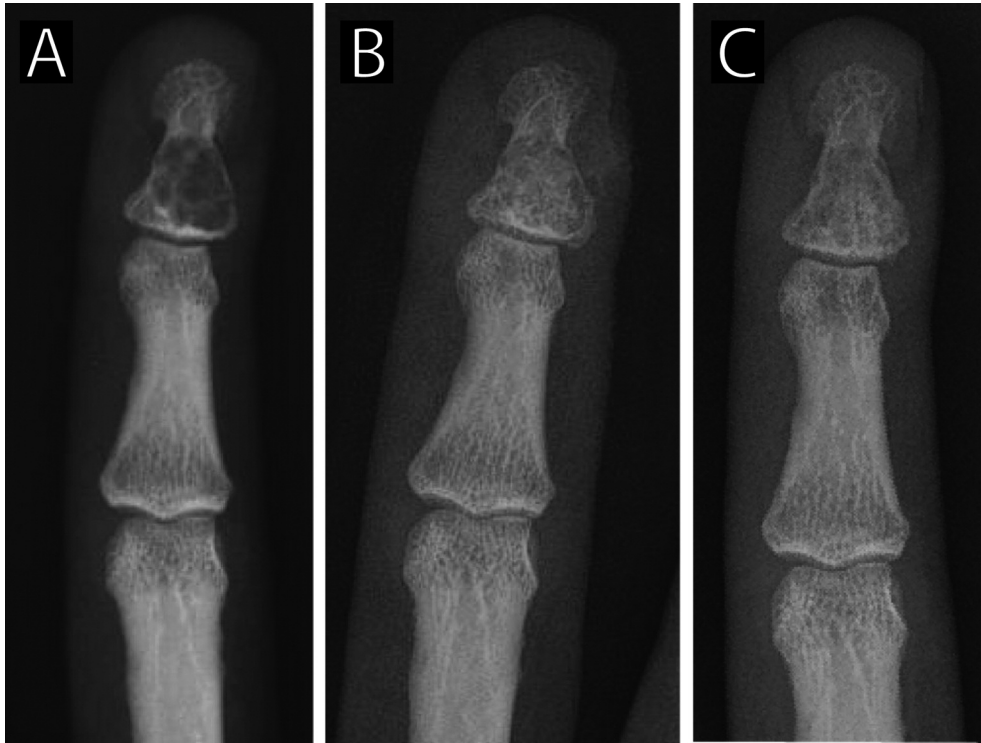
Plain radiographs from the case of a 35-year-old female with distal phalanx enchondroma at presentation (A), and at 3 months (B) and 1 year (C) after treatment with curettage and autogenous bone grafting.
